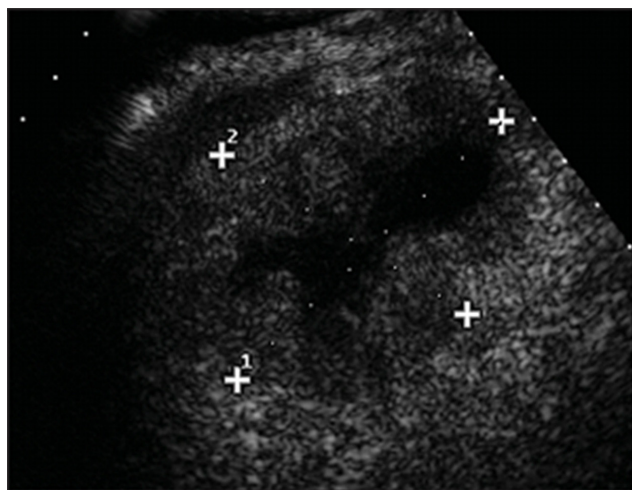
Right intercostal contrast-enhanced sonogram showing a 7 cm × 6 cm colorectal metastasis of the right liver lobe
